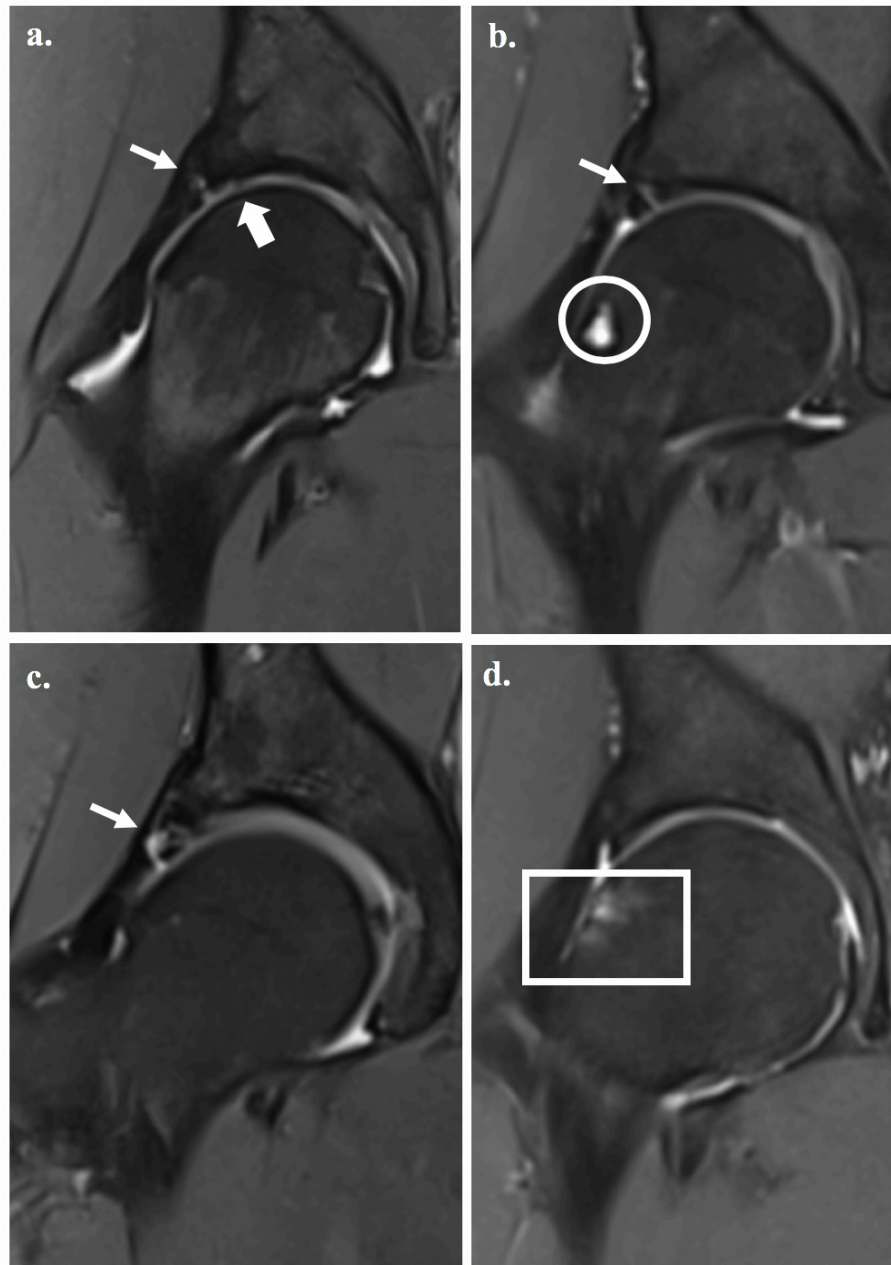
Coronal Dixon MR images showing intraarticular abnormalities in 4 volunteers, in ‘in-phase’ MRI sequences: a) Non-marathoner 1 with labrocartilage separation (small arrow) and full thickness cartilage defect (big arrow); b) Non-marathoner 2 with simple labral tear (small arrow) and subcortical cyst (circle); c) Marathoner+ 1 with complex labral tear (small arrow); d) Non-marathoner 3 with subchondral BME (square); SHOMRI grading system [208] was used in the assessment of labrum, cartilage, bone marrow; SHOMRI, Scoring Hip Osteoarthritis with MRI; BME, bone marrow edema.
